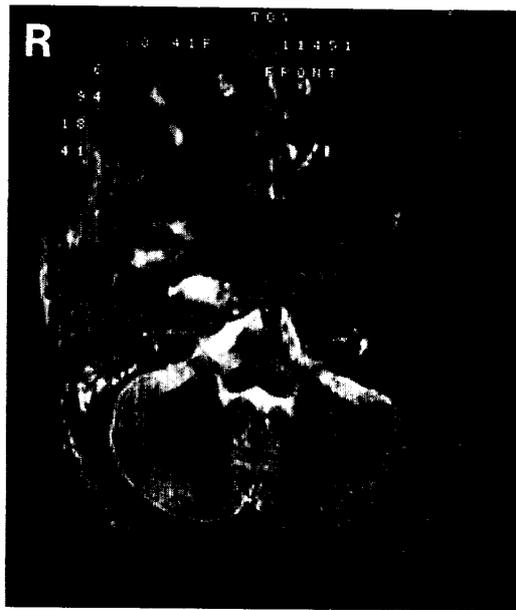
Postoperative T₂-weighted magnetic resonance image showing no fluid in the middle ear.
